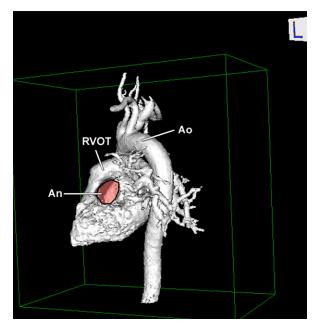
Cardiac magnetic resonance image (3-dimensional reconstruction) shows the location of the thrombosed aneurysm (An) at the aortic root, extending to the right ventricular outflow tract (RVOT).
